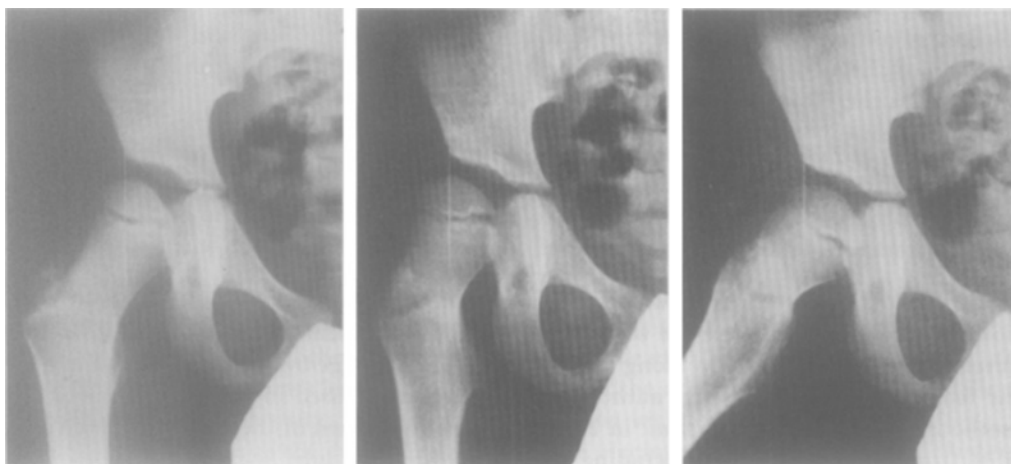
The same hip joint has been radiographed (a-p view) in a) maximum internal rotation. b) neutral rotation. c) abduction.
